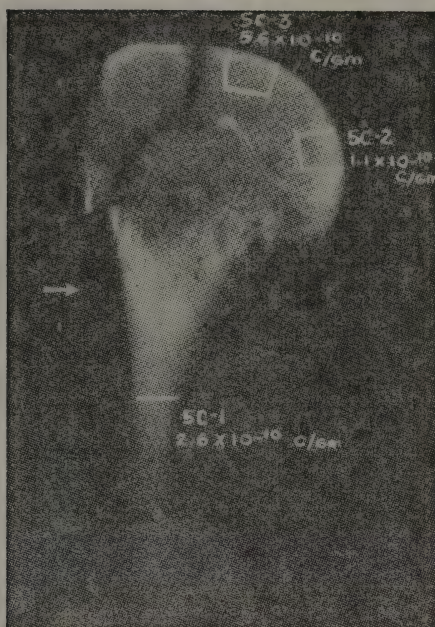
Roentgenogram of a 2-millimeter section taken from the head of the right humerus. (See fig. 6.) Sections of bone, 5C-2 and 5C-3 were removed following the making of gross autoradiographs of this bone section. As will be noted in the figure, 5C-2 was taken from an area which seemed to have a large concentration of radium as shown by gross autoradiography; 5C-3 was taken from an area which seemed to have a small amount of radium as shown by gross autoradiography and a normal roentgenographic pattern. It should be noted that the radium content in RC-3 was five times the content in RC-2. Radium values are expressed as curies per gram of ashed bone. (Reproduced courtesy of the Journal of Bone and Joint Surgery.)
